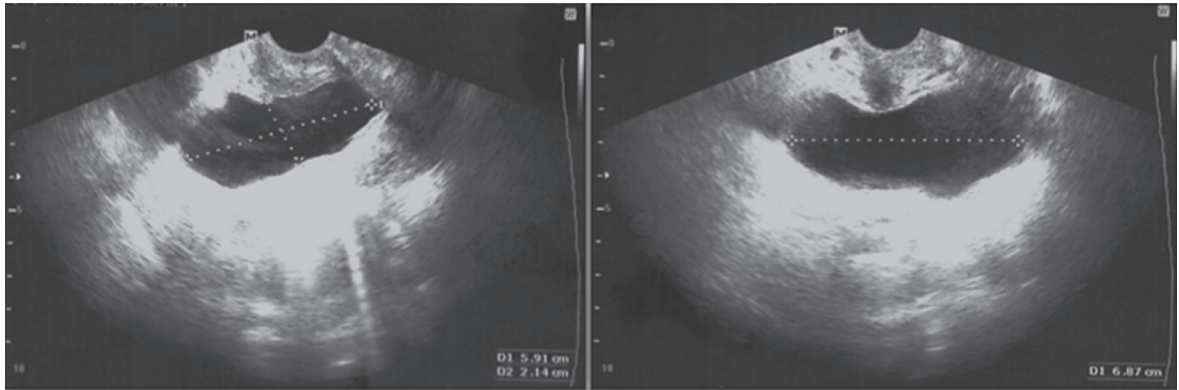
Measurement of bladder using transvaginal ultrasonography
